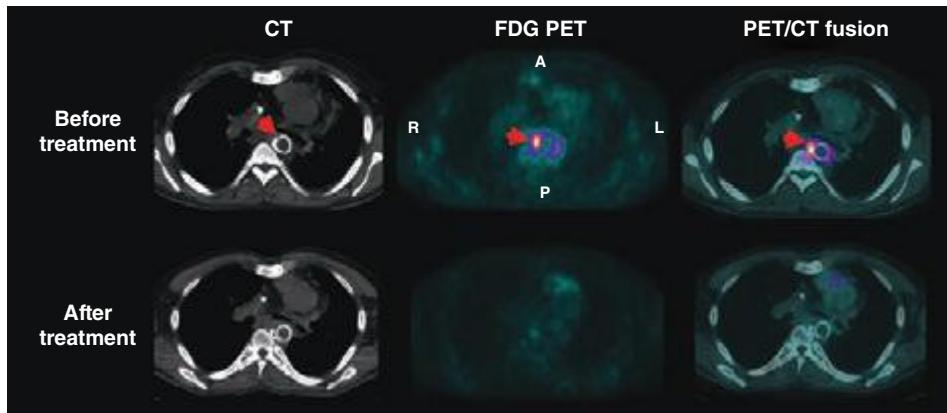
36 Representative cross-sectional computed tomography (CT; *left*), fluorodeoxyglucose (FDG) positron emission tomography (PET; *middle*), and fused CT and PET (*right*) images before and after antibiotic treatment in a patient with fever and suspected infection of the stent placed in the descending portion of the aortic arch (arrow) for treatment of aortic coarctation. The FDG images before treatment demonstrate intense glucose uptake within the stent, consistent with inflammation/infection. The *lower panel* demonstrates significant attenuation of the FDG signal after treatment. (*Images courtesy of Dr. Sharmila Durbala, Brigham and Women's Hospital.*)
